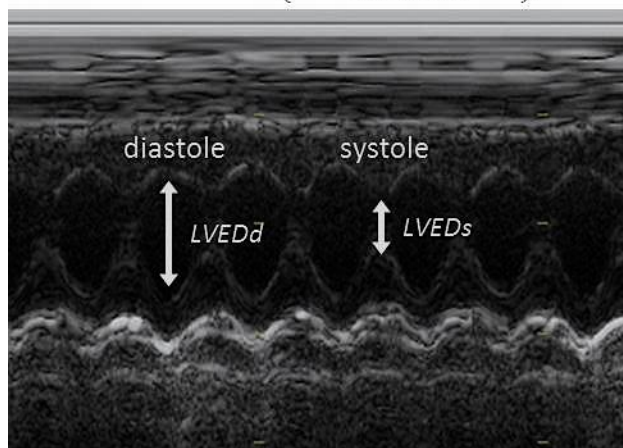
Heart function is evaluated by fractional shortening (%FS), which is analyzed using echocardiography. The equation above is used to calculate %FS, where LVEDd = LV end diastolic dimension and LVESd = LV end systolic dimension.
